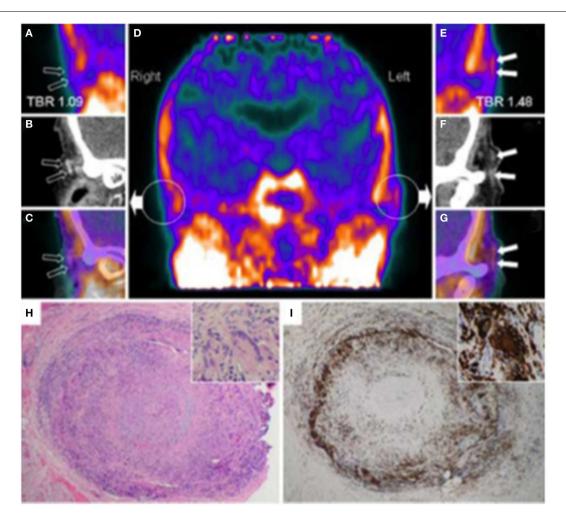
Hybrid PET with PK11195 and CT angiography imaging of an 88-year-old woman presenting with left scalp tenderness, jaw claudication, and night sweats. The coronal reconstruction (D) and magnifications of PET (A,E), and contrast-enhanced CT (B,F) and PET/CT fusion images (C,G) show focal PK11195 uptake in the left temporal artery above the zygomatic process (solid arrows) compared to the contralateral artery (open arrows). The arterial target-to-background ratio (TBR) was higher in the left than in the right temporal artery. On CT angiography, the left temporal artery lumen (1.8 mm diameter) was irregular with reduced contrast opacification compared with the contralateral (2.2 mm diameter).
